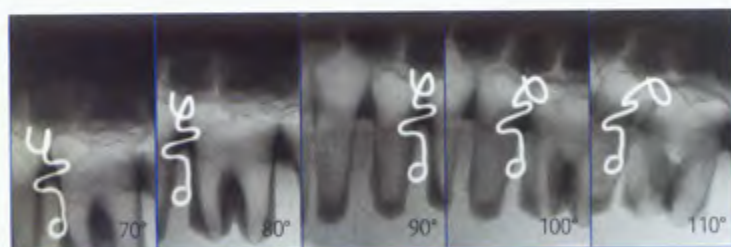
The position of the eyelet was not changed for all radiographs. The angle between the X-ray tube and X-ray film was changed. Plus or minus 10 degrees from square or right angle (perpendicular) leads to false positive results. An artificial skull was used for the pictures.
